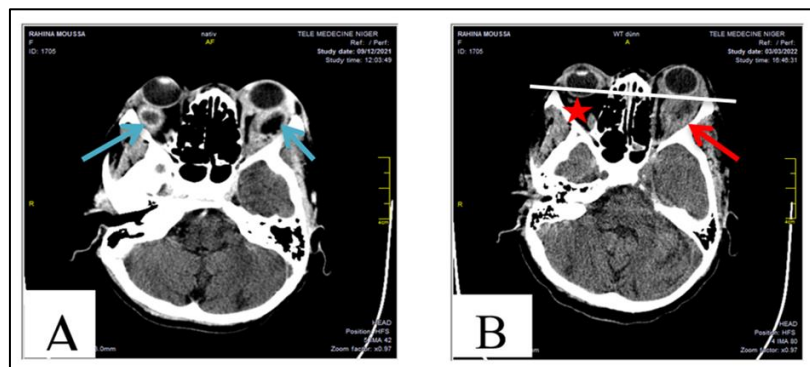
(A) CT scan with bilateral orbital cystic foci (see blue arrows), (B) CT scan after 3 months of antibacillary treatment with disappearance of the abscess on the right (red star) and of the exophthalmos and regression of the focus on the left with deterioration of the exophthalmos to grade II (red arrow)
